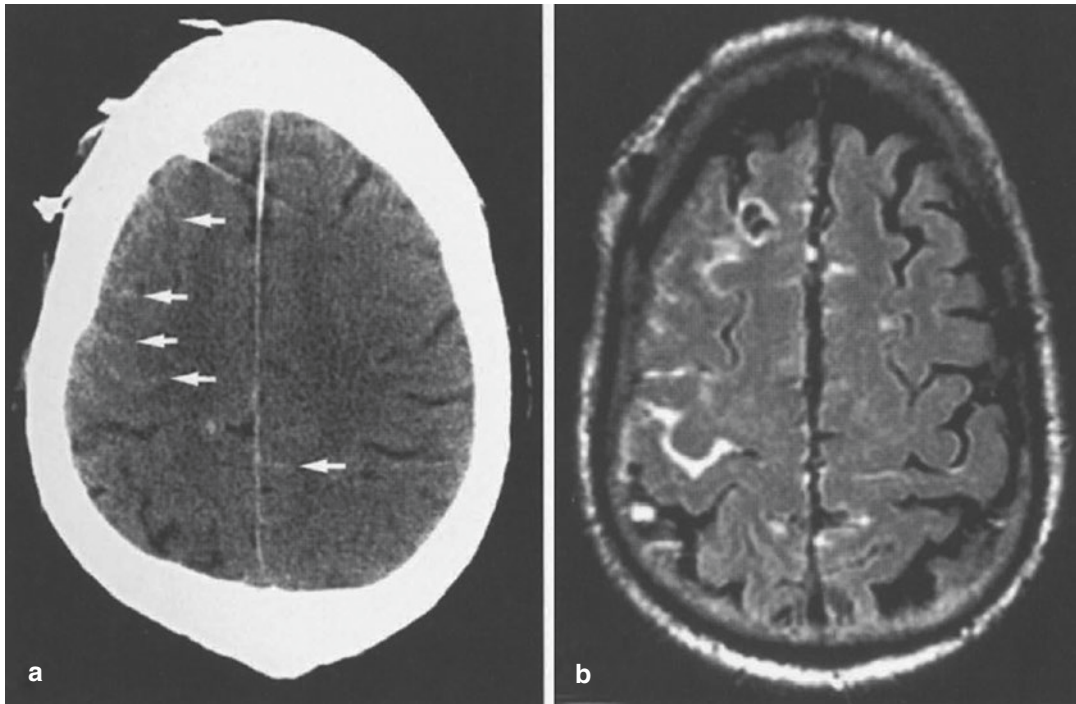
(a–d) Subarachnoid hemorrhage in a 68-year-old man with ruptured aneurysm of the right middle cerebral artery bifurcation. (a) Postoperative CT shows subtle high density of subarachnoid space in the right frontoparietal area (arrows). (b) FLAIR image shows subarachnoid
